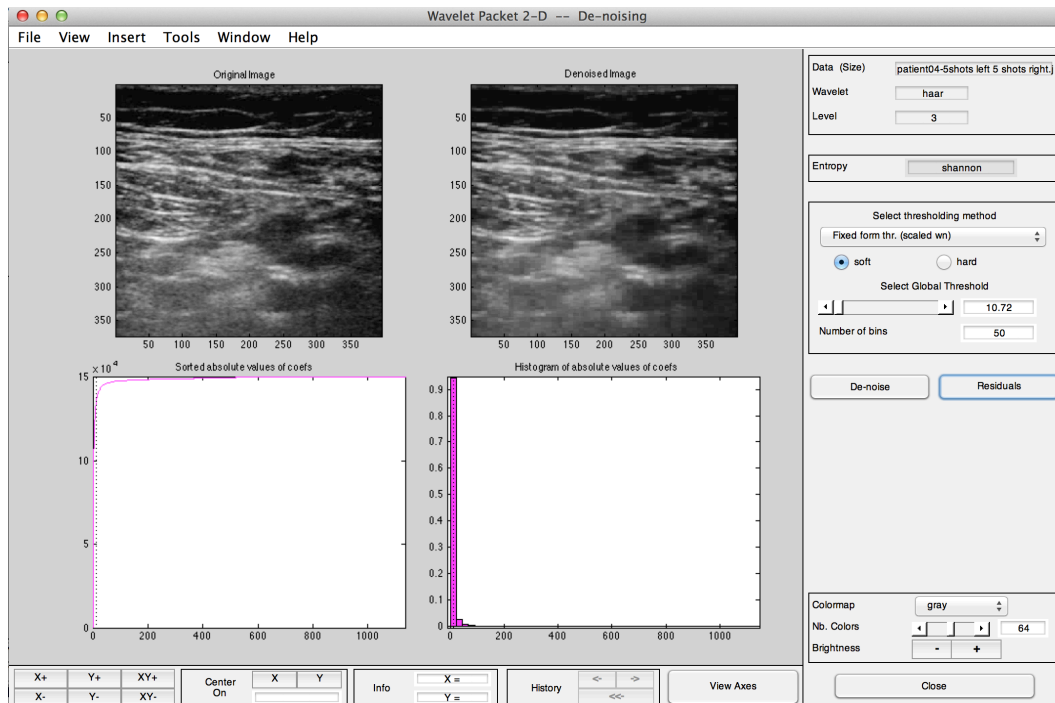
MATLAB's wavelet toolbox being used for an ultrasound image
